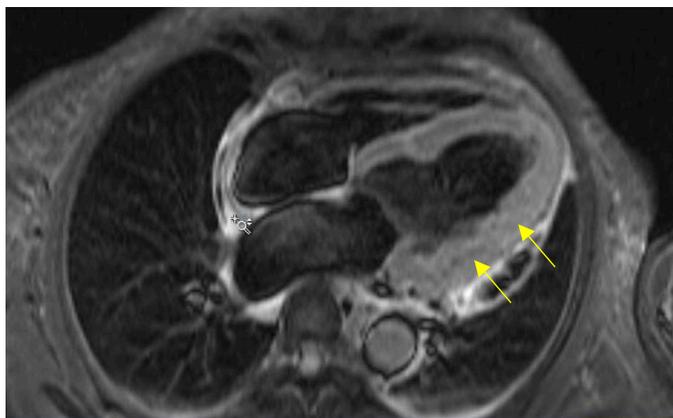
Cardiac MRI demonstrating myocardial enhancement and edema (yellow arrows), indicating evidence of myocarditis
